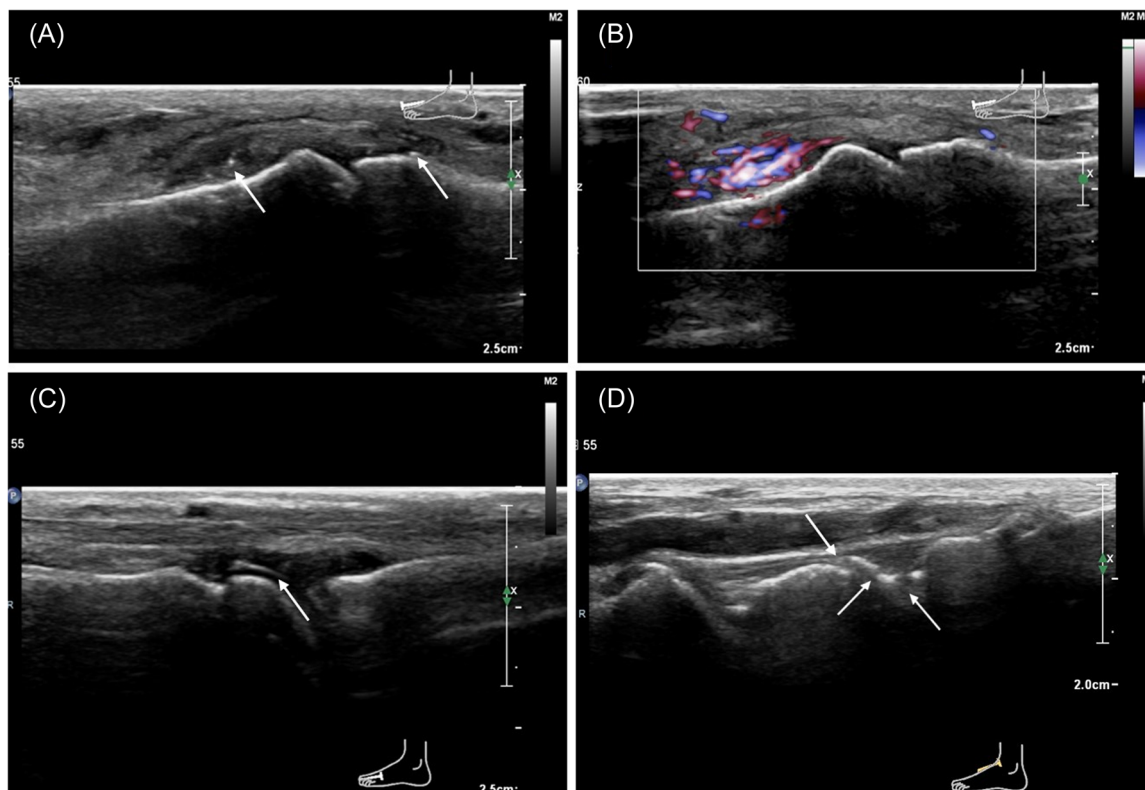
(A) Deposition of urate crystals in the first MTP joint of GA. Longitudinal ultrasound image shows synovial hyperplasia, multiple punctate hyperechoic (arrow). (B) Synovitis. Longitudinal ultrasound images of the first MTP joint power Doppler ultrasonography shows abundant blood flow signals (PDS: grade 3). (C) Ultrasound double contour sign. Longitudinal ultrasound image of the second metatarsophalangeal joint shows hyperechoic enhancement (arrow) over the surface of the hyaline cartilage. (D) Bone erosion. Ultrasound appearance of erosion in the talus demonstrates cortical irregularity, focal defect (arrow). GA, gouty arthritis; MTP, metatarsophalangeal; PDS, power Doppler ultrasonography.
